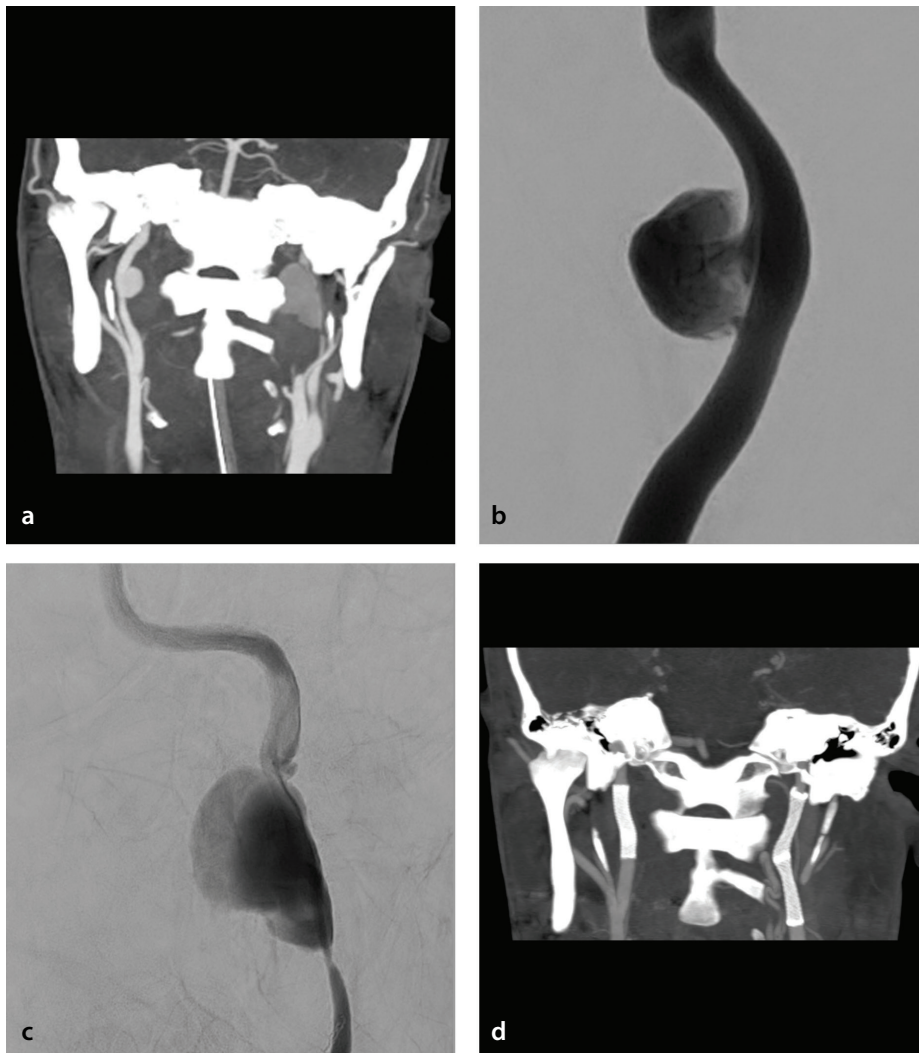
Patient 3: Bilateral acute traumatic dissecting aneurysms. (a) Computed tomography (CT) angiography reveals a bilateral high-cervical internal carotid artery (ICA) dissection accompanied by sacular (R) and fusiform (L) aneurysms. (b, c) Angiograms show more clearly the anatomy of the right (b) and left (c) cervical ICA aneurysms. (d) Six-month control CT angiography confirms the disappearance of both aneurysms and the normal calibration of the dissected segments.
